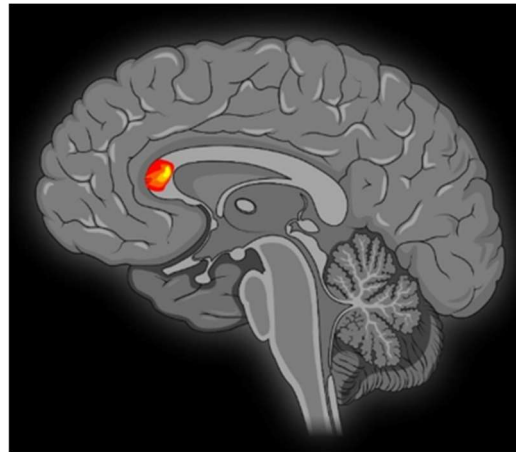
A sagittal MRI sequence is shown, which shows significant neural activity in the right anterior cingulate cortex (BA 24), left anterior cingulate cortex (BA 24), and left medial frontal gyrus (BA 10).
